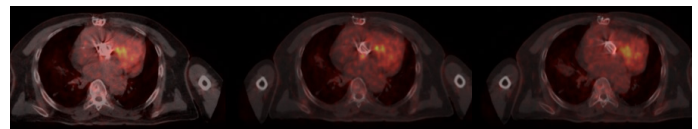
PET and CT images of the case with IE
